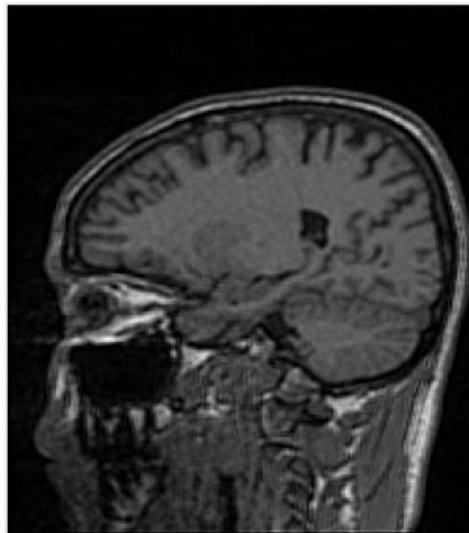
2D MRI cortex image after the unsharp filter
